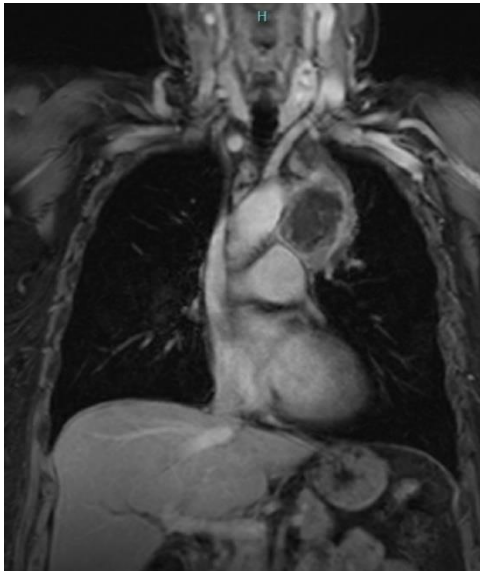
Magnetic resonance image of anterior mediastinal mass.
